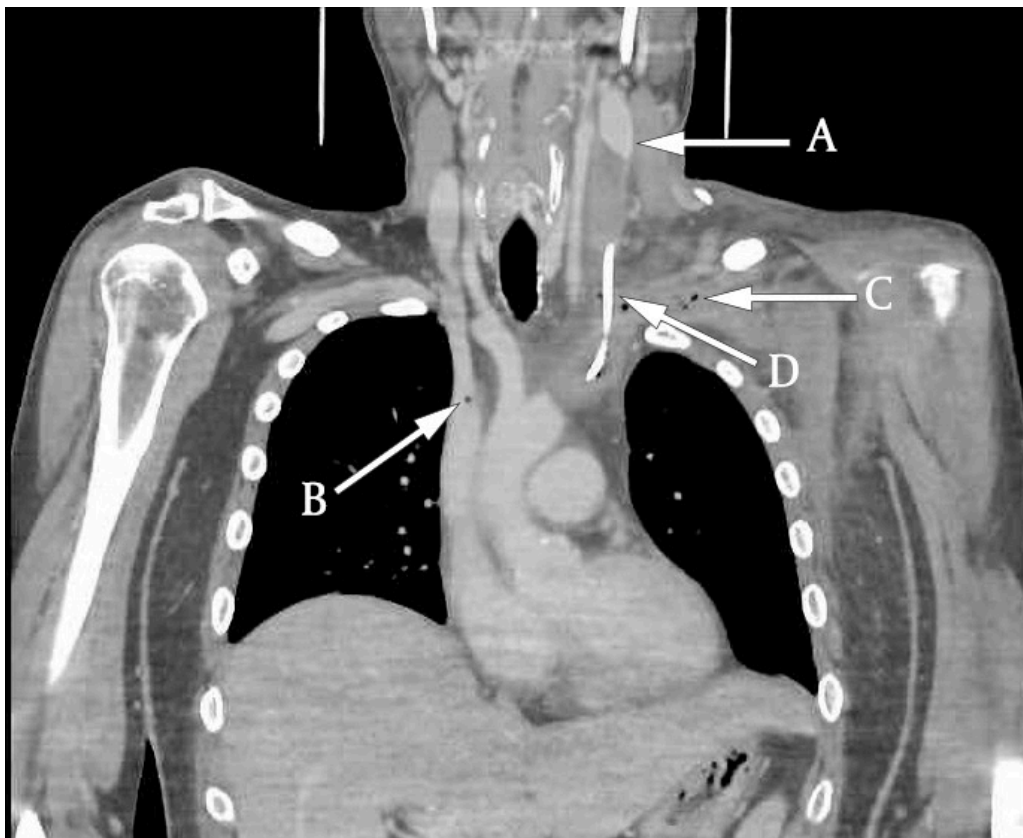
CT venography showing the extent of the thrombotic mass. Arrow A shows the transition between free lumen and thrombotic mass in the left internal jugular vein. Arrow B shows air in the thrombotic mass, which extends into the superior vena cava. Arrow C shows air bubbles in the thrombotic mass in the left subclavian vein and around the catheter. Arrow D shows the catheter. Note also the swelling on the left side of the neck and throat.
